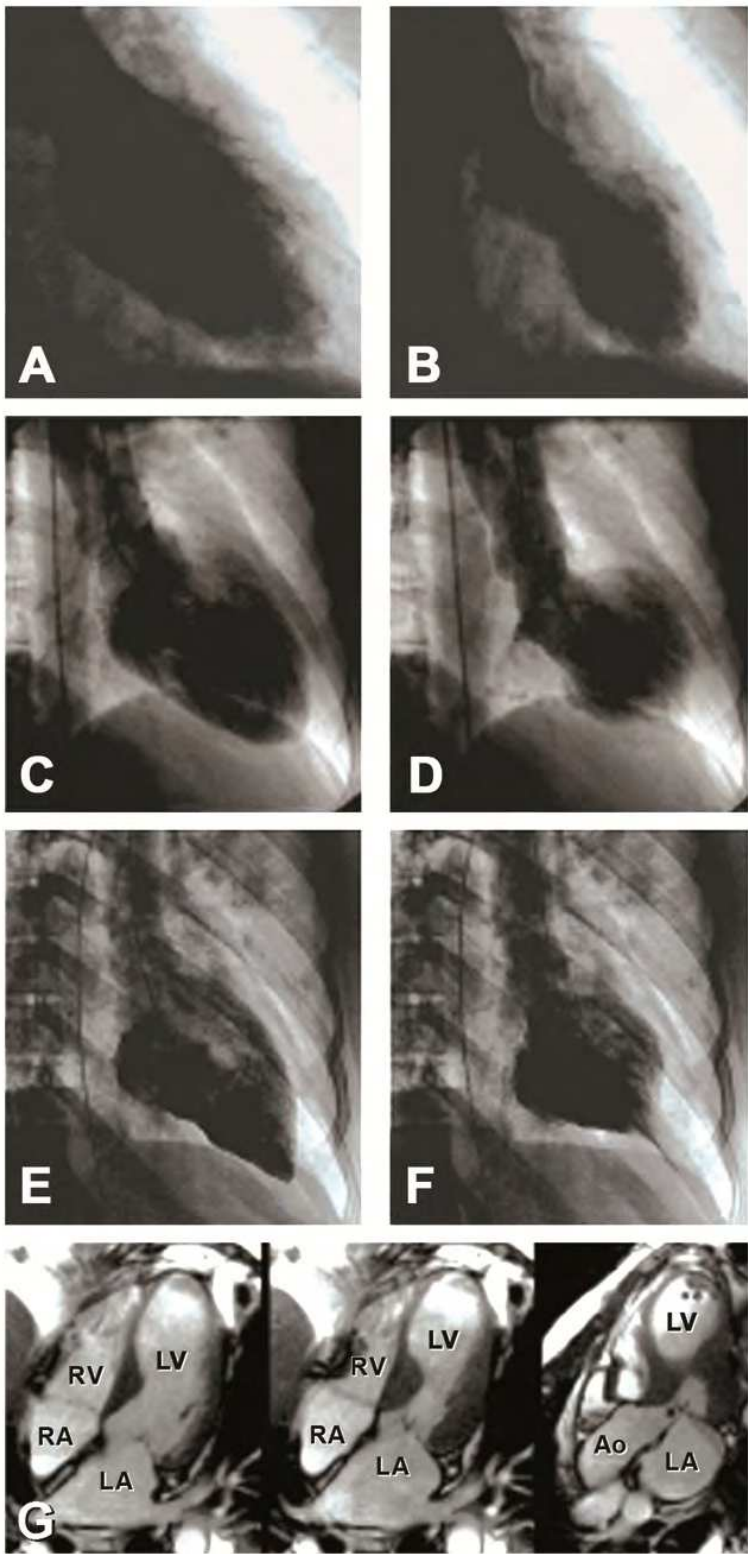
Radiograph of the left ventricle. (A) Left ventriculogram in diastole. (B) Left ventriculogram in systole shows preserved contraction of the base of the ventricle and apical ballooning. (C) Right anterior oblique view in diastole. (D) Right anterior oblique view in systole. Note the hypercontractility of the basal and apical segments and ballooning of the midventricular segments. (E) After methamphetamine use in end-diastole. (F) After
